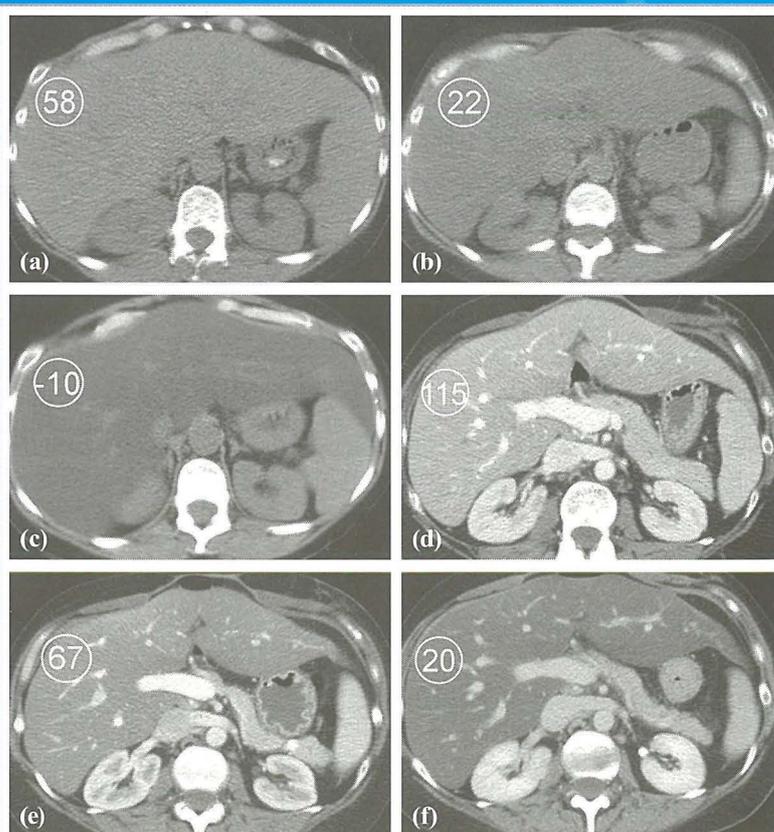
Fatty infiltration of the liver parenchyma in a 46-year-old woman with ovarian cancer who was undergoing chemotherapy. Sequential nonenhanced (a–c) and portal venous perfusion phase contrast material-enhanced (d–f) CT scans obtained at 3-month intervals show a progressive decrease in hepatic attenuation. Circle = region of density measurement, number = attenuation in Hounsfield units.
